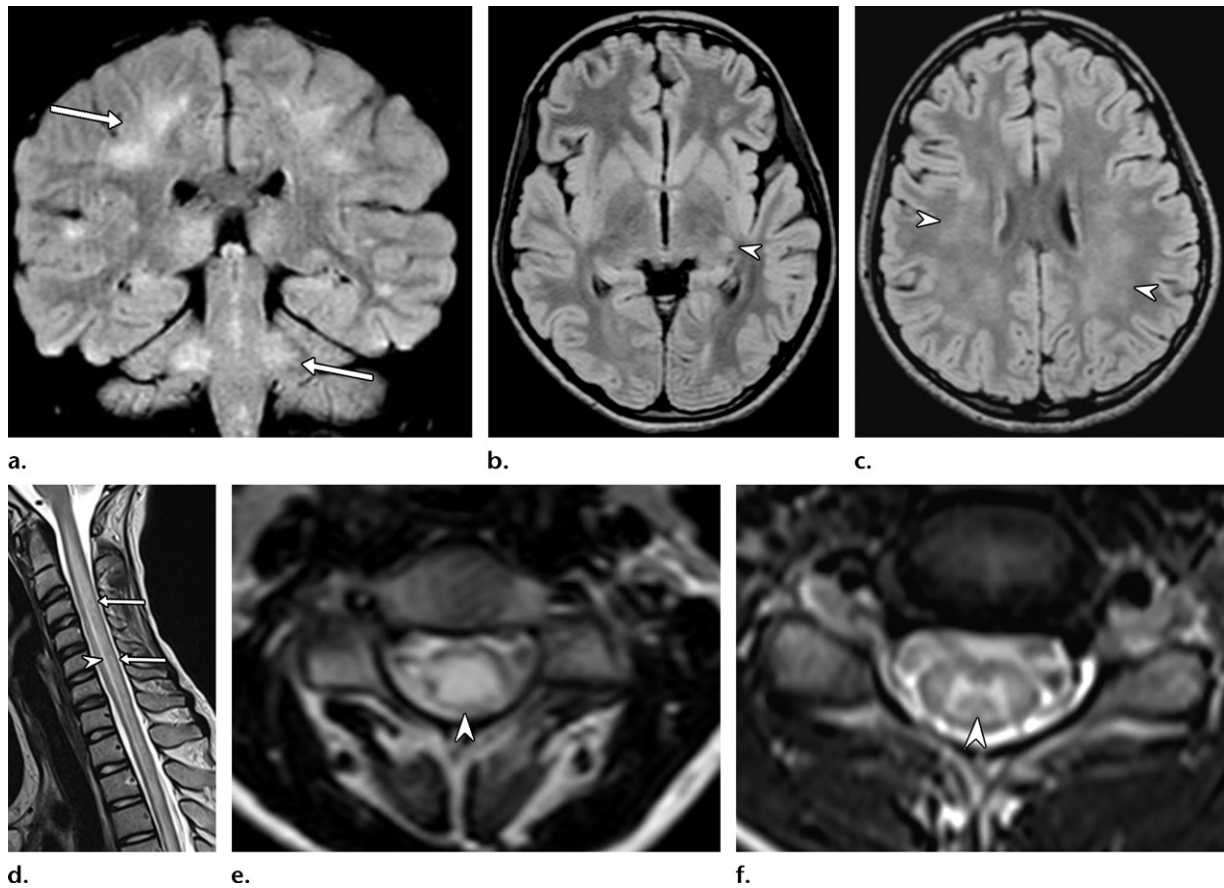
MOG antibody-associated ADEM in a 12-year-old girl with encephalopathy, ataxia, and lower extremity weakness after a viral illness. (a) Coronal FLAIR image shows large and blurred hyperintense lesions (arrows) involving both cerebral hemispheres and the cerebellar peduncles. (b, c) Axial FLAIR images show hyperintensity in the left thalamus (arrowhead in b) and widespread poorly demarcated lesions in the white matter (arrowheads in c). (d) Sagittal T2-weighted image shows a sagittal hyperintense line (arrowhead) surrounded by hyperintensity (arrows) in the cervical cord extending to the thoracic cord. (e, f) Axial T2-weighted images show abnormal hyperintensity that involves both the gray and white matter (arrowhead in e) and the central gray matter in an H-type configuration (arrowhead in f).
